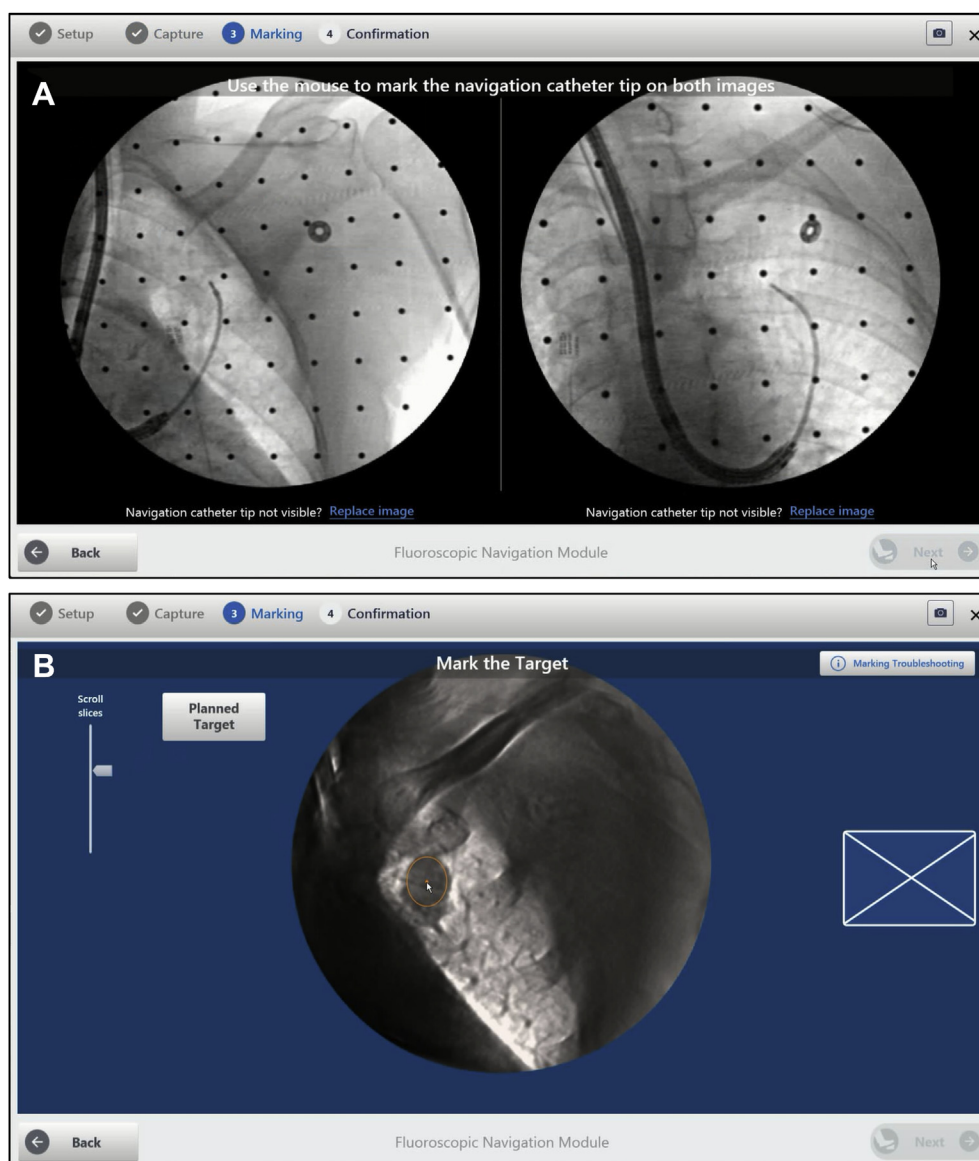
Most recent version of the ENB-SD system. A, Without CT-to-body divergence correction with ENB-SD fluoroscopic navigation. B, Six-millimeter error corrected with ENB-SD local registration and confirmed by cone beam CT scans. Images courtesy of Krish Bhadra, MD, all rights reserved. ENB-SD = electromagnetic navigation bronchoscopy-superDimension navigation system.
